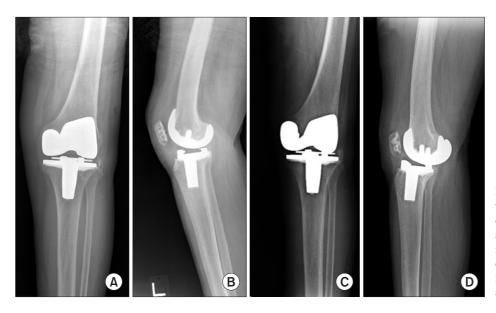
Radiographs of a 60-year-old woman with rheumatoid arthritis. (A, B) Images obtained 2 months after manipulation show a good alignment. However, stiffness that restricted the range of motion to 70° recurred. (C, D) Radiographs at 9 years and 7 months after surgery showing 0° extension ankylosis of the knee joint.
